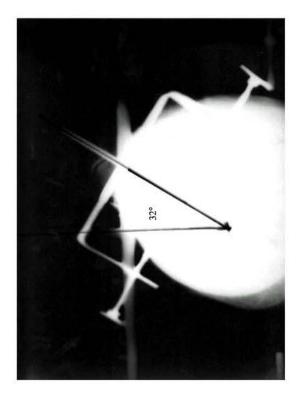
Calculation of tibial rotation on X-Ray film
